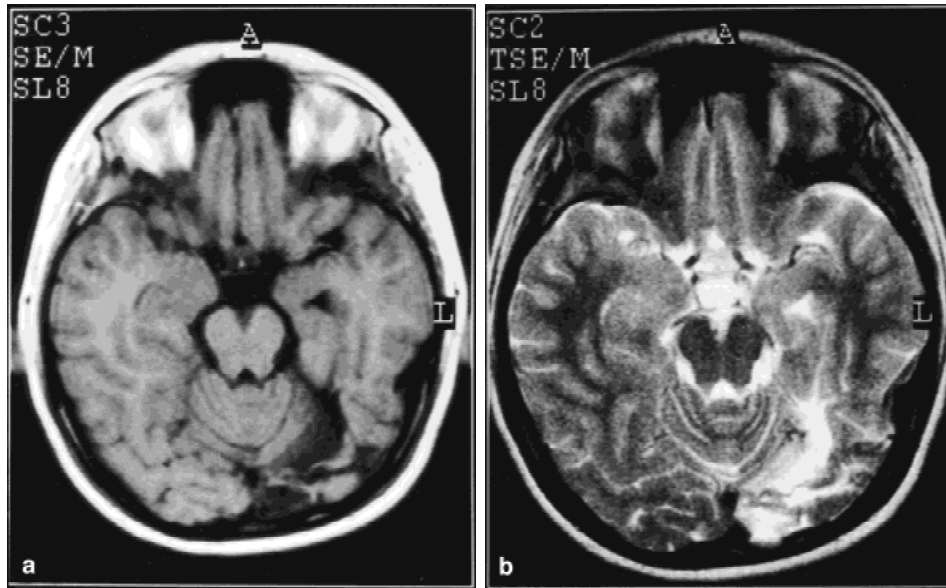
Magnetic resonance imaging of the patient. T1-weighted image (a) shows secondary focal dilatation in the left lateral ventricle and focal cortical and subcortical matter loss in the left posterior occipital area, pointing to an old infarct. The lesion is hyperintense in the T2-weighted image (b).
